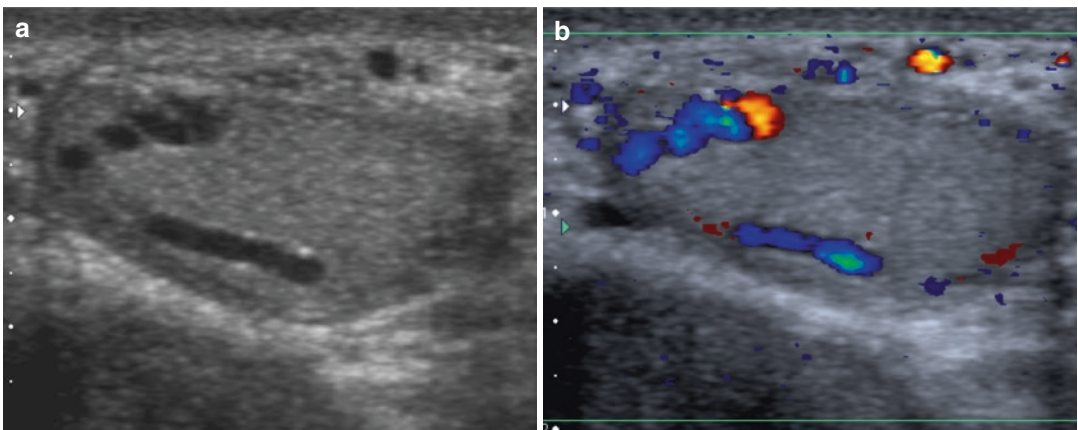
Intratesticular varicocele. (a) Gray-scale ultrasonography shows intratesticular anechoic tubular structures within the testis. (b) Color Doppler interrogation
